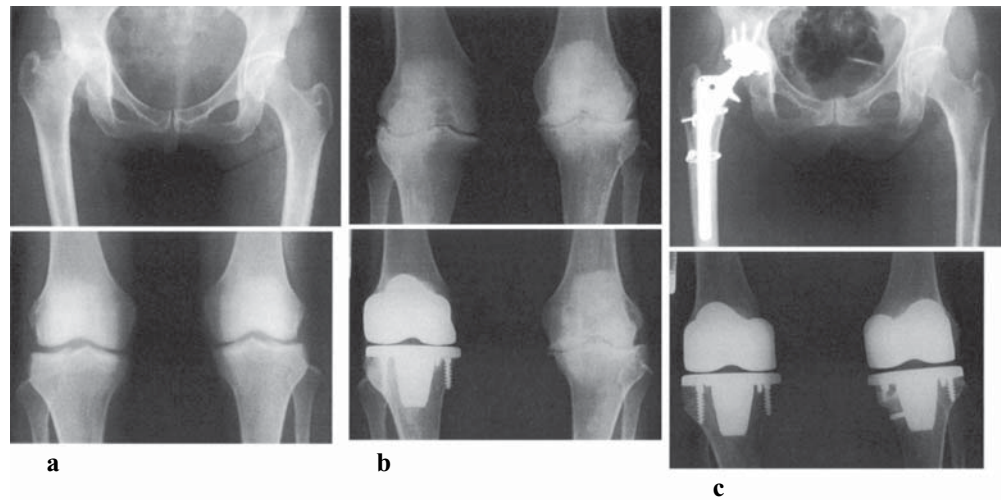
Case 3. a The X-ray finding prior to right THA using HG hybrid for right hip destruction. No remarkable changes in the knee joints were observed. b Right knee joint destruction progressed over 6 years (*upper*) and right TKA using Magna ROM21 was performed.
